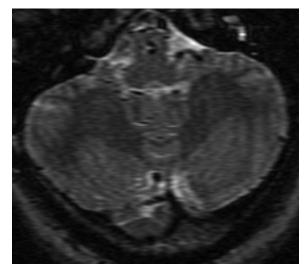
Axial T2-weighted brain magnetic resonance imaging shows multiple perimedullary and left cerebellopontine angle serpiginous flow voids.
